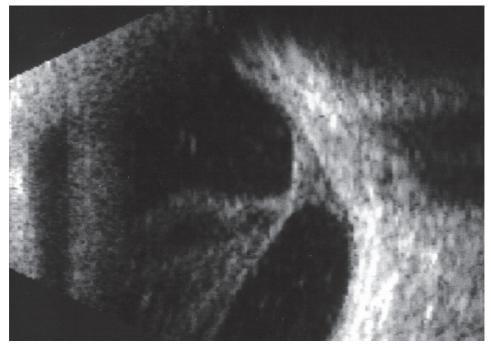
Ultrasonography revealing a funnel-shaped structure and adhesion to the optic disk in a child with ocular toxocariasis.
